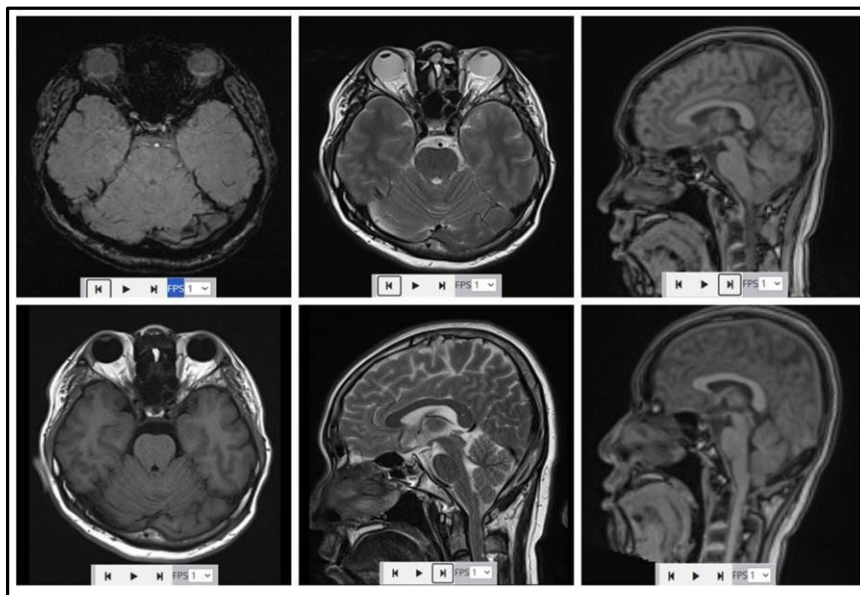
Head MRI results on June^{12th} 2024, Impression, no visible pituitary adenoma; cavum septum pellucidum et vergae; no visible images of infarction, bleeding, infection or intracranial mass, and no nasal septum deviation visible.
